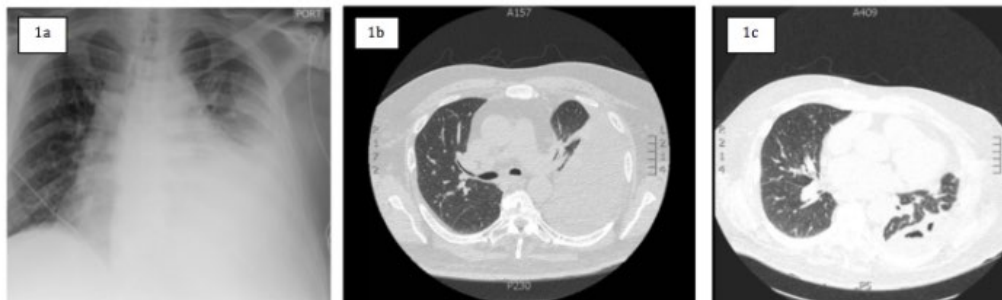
a) Chest X-Ray at presentation to our institution demonstrating a large left-sided pleural effusion. Figure 1b) Chest CT prior to chest tube placement demonstrating large left-sided pleural effusion. Figure 1c) Chest CT several days after chest tube placement demonstrating a partially loculated residual pleural effusion.
